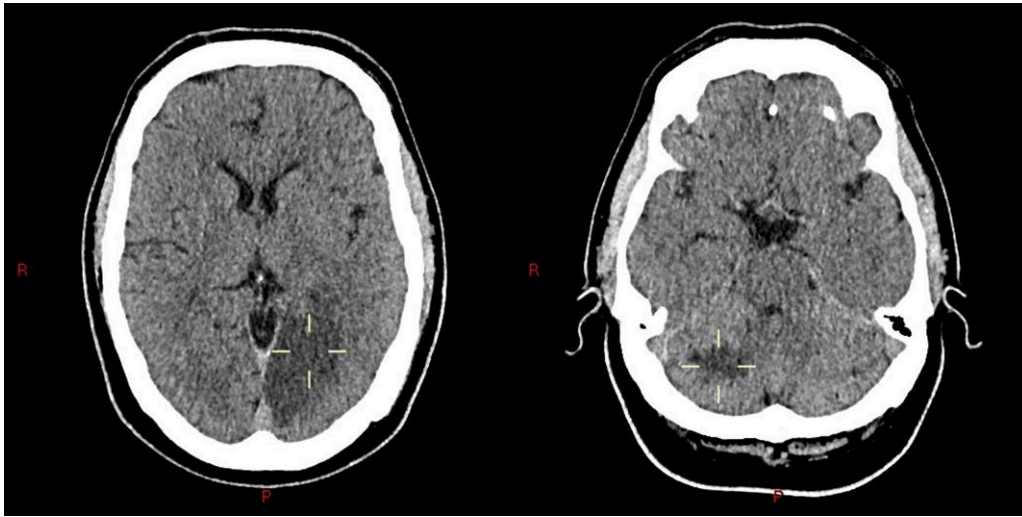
CT brain. Markers demonstrate acute left occipital lobe and right cerebellar infarcts.
